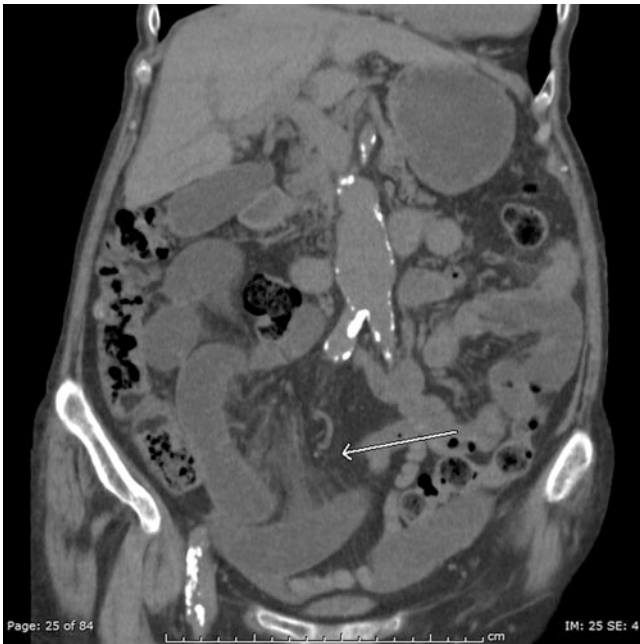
Coronal CT showing closed loop obstruction with mesenteric twists. Note fluid filled dilated small bowel obstruction
